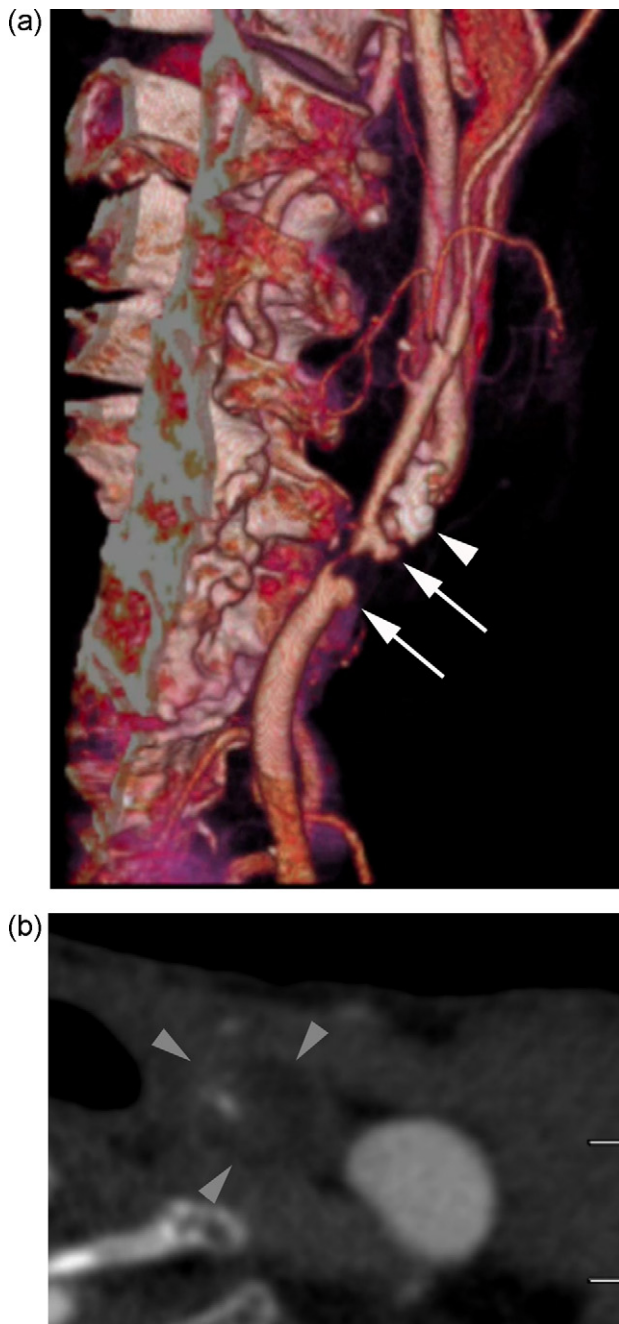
CTA of the supra-aortic trunks. (a) Volume-rendered 3D reconstruction showing an 83% stenosis of the distal CCA, with ulcerated plaque (arrows). There is also a calcified plaque of the proximal left ICA (arrowhead). (b) Axial source images showing soft atheromatous plaque (arrowheads).
